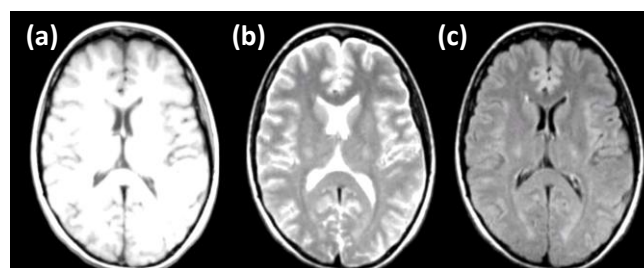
Types of MRI modalities (a) T1w, (b) T2w, and (c) FLAIR
